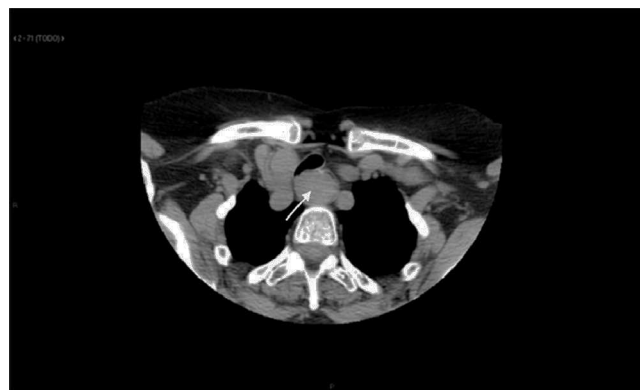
Cervicothoracic computed tomography: lesion in the cervical esophagus that practically closes the esophageal lumen.
